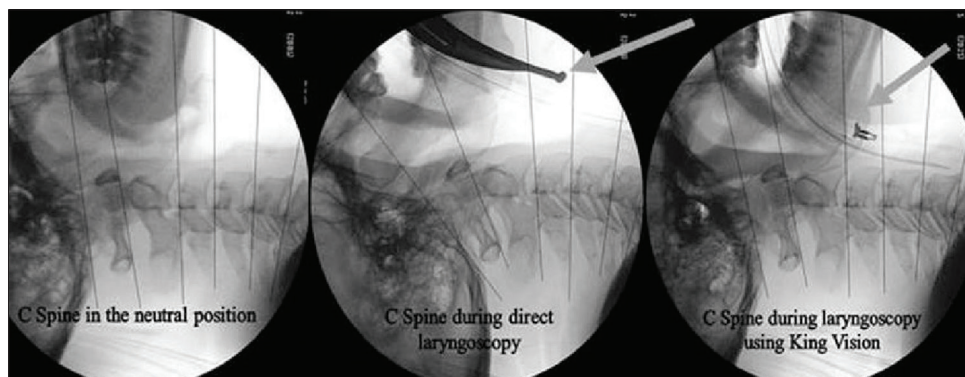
Lateral X-ray view of the cervical spine with Macintosh direct laryngoscope and King Vision video laryngoscope showing amount of extension required at cervical spine for intubation.
